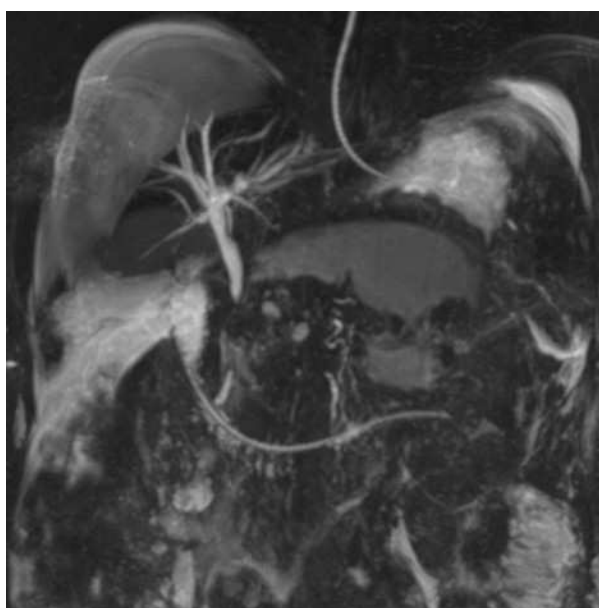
MRI abdomen on day 28 showing pancreatic necrosis compressing on the common bile duct.
